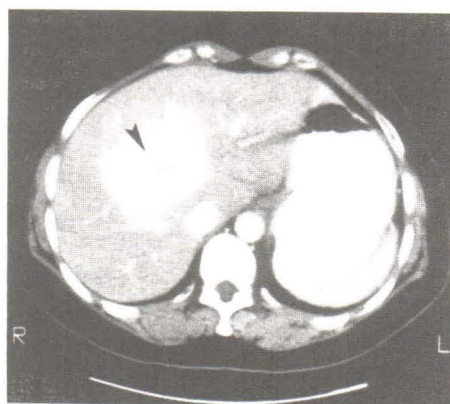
Same case as in Figure 1, follow-up Lipiodol CT scan after TOCE of inferior phrenic artery shows complete opacification with lipiodol of HCC (arrow).
